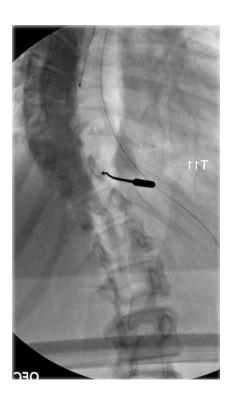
Intraoperative X-ray from initial procedure at right T11 pedicle.
